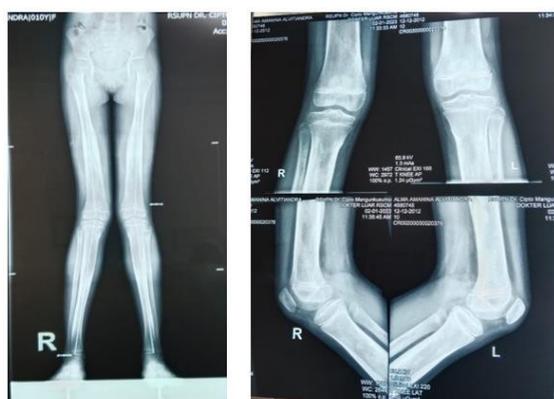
X-ray examination results of the patient (Source: personal documentation)
